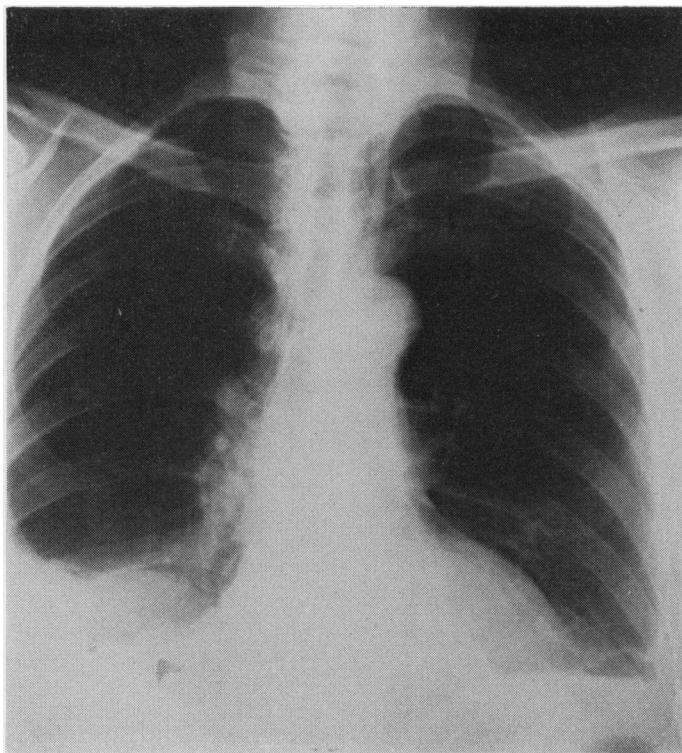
Case 2. Chest radiograph showing bilateral pleural fibrosis.
